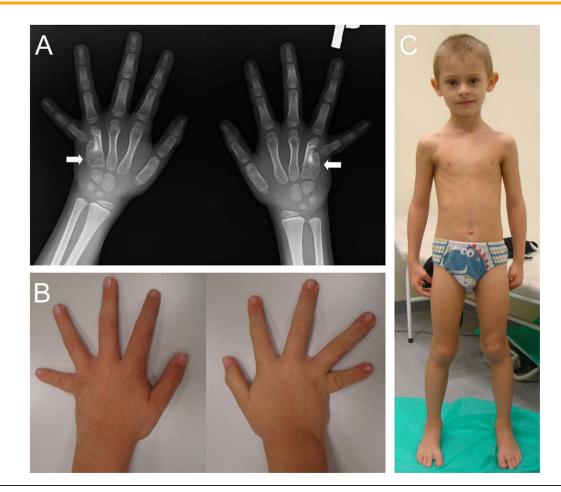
Upper limb malformation observed in our proband. (A) Radiograph of the hands showing bilateral partial fusion of metacarpals 4 and 5 and bilateral shortening of fifth metacarpals. (B) Ulnar deviation and shortening of fifth fingers seen upon clinical assessment. (C) Frontal view of the proband showing his slender built.
